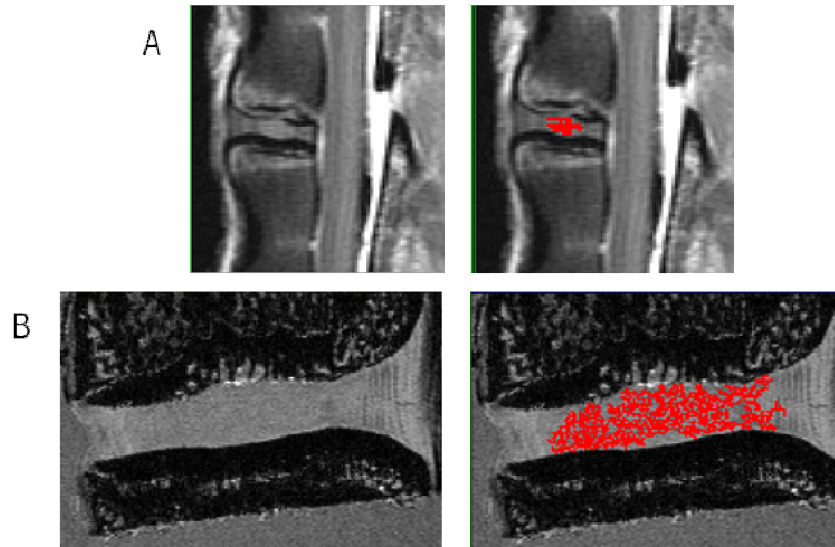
The Canny Operator applied to the (A) MR and (B) micro-MR images after thresholding.
